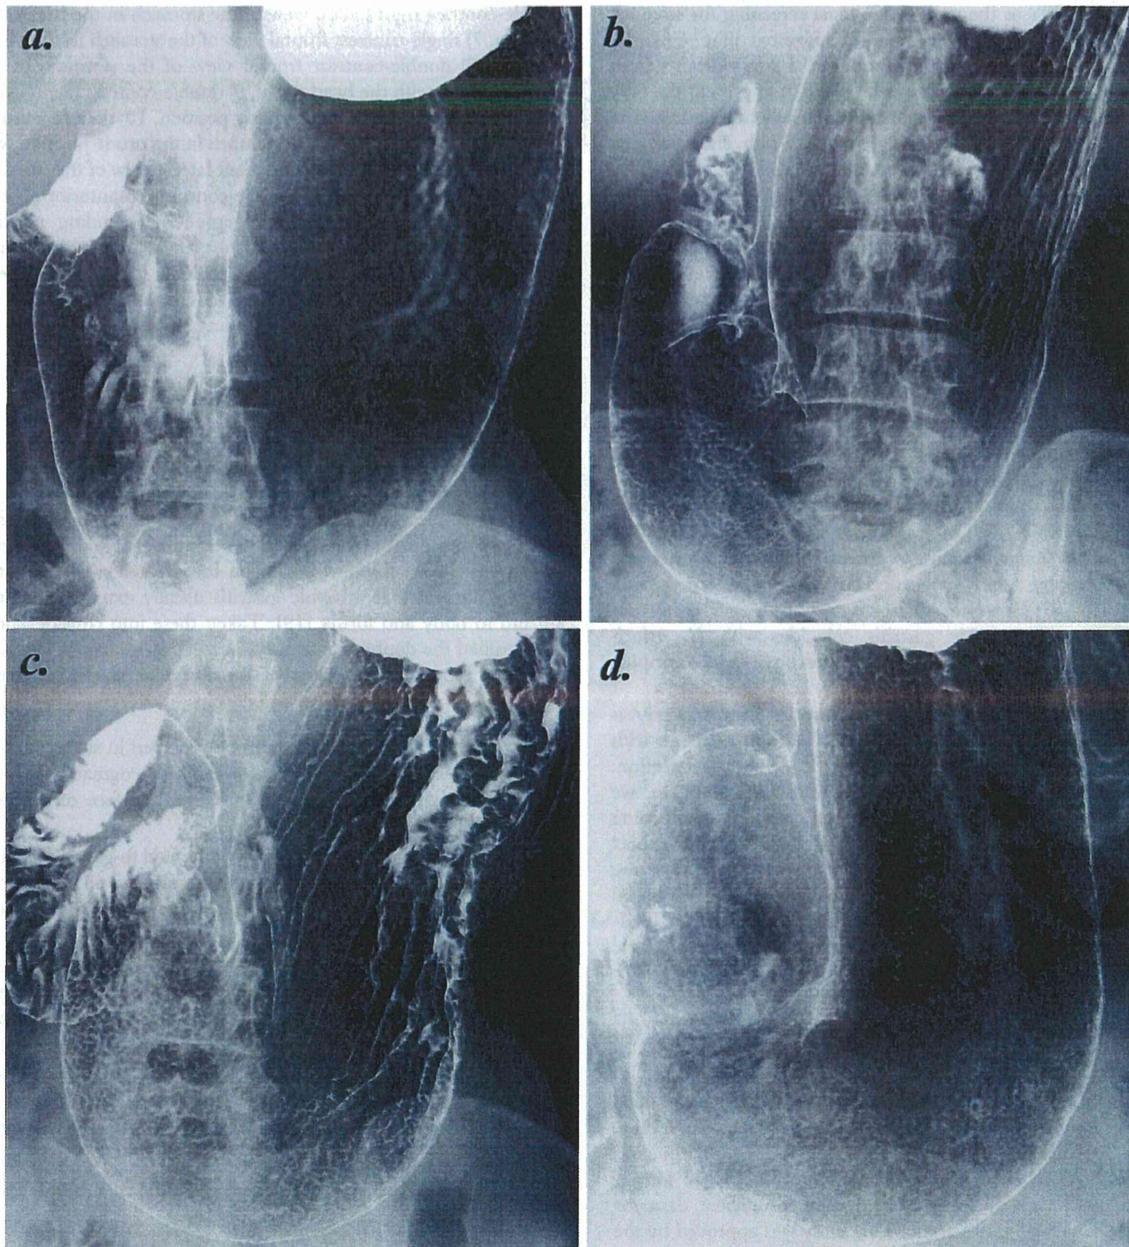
Typical four images of stomach by double-contrast upper gastrointestinal barium X-ray radiography (UGI-XR). (a) Normal stomach with no atrophic change of gastric mucosa. (b) Mild gastritis in which atrophic change mostly exists in gastric antrum and angle, accompanied with slightly enlarged irregular areae gastricae. (c) Moderate gastritis in which atrophic change extends from gastric antrum to body and/or fornix, accompanied with obviously enlarged irregular areae gastricae. (d) Severe gastritis in which atrophic change covers the entire stomach, accompanied with obscured small or even absent areae gastricae. doi:10.1371/journal.pone.0111359.g001
